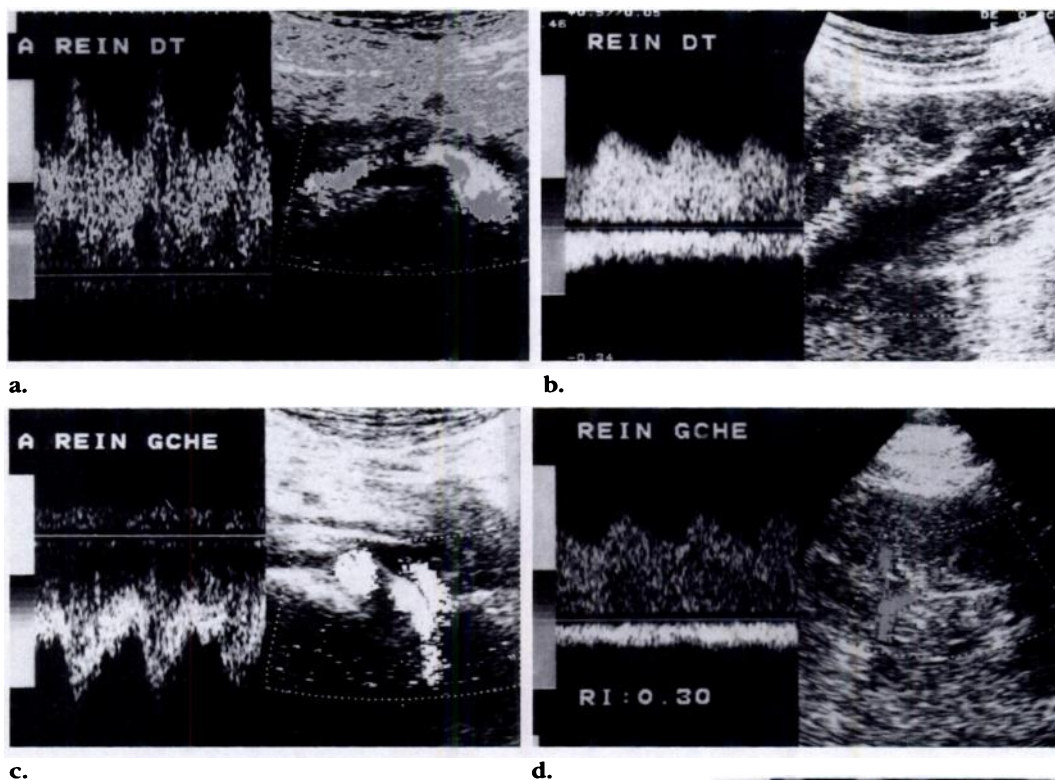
Coarctation of the aorta. (a–d) Doppler spectrum (left) and sonogram (right) demonstrate hemodynamic changes in the right (a, b) and left (c, d) kidneys and in the whole renovascular bed, including low-resistance waveforms and delayed and blunted systolic peaks in the intrarenal arteries (b, d). Such findings are highly suggestive of a stenosis of the aorta upstream from the RAs. (e) Aortogram shows severe coarctation of the aortic arch (arrow).
